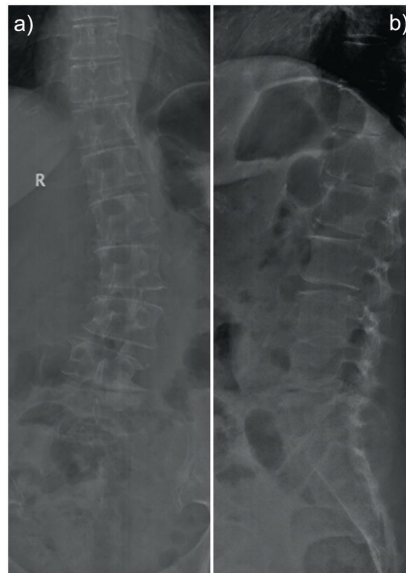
Shown are anteroposterior (a) and lateral (b) views of the lumbar spine showing scoliosis with a measured Cobb angle of 32°. The patient's radiographic sagittal balance examination shows loss of normal lordosis with some lumbar spine flattening.
